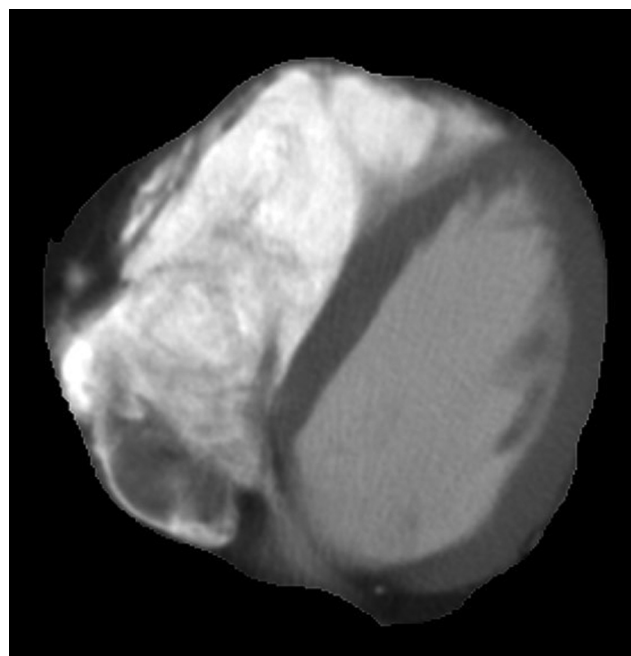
Axial CT image of an epicardial region of interest (ROI) after tracing the pericardium, leaving the epicardial fat concentrated in the atrioventricular grooves, interventricular grooves, along the major branches of coronary arteries, around the atria, over the free wall of the right ventricle, and over the apex of the left ventricle.
